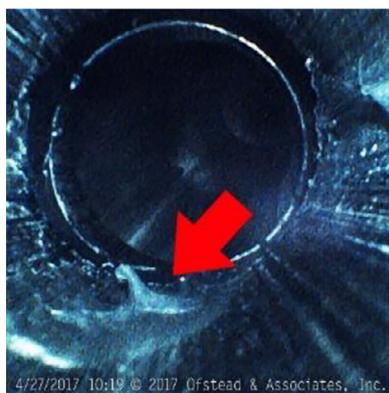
Solid mass protruding into the channel of an endoscopic ultrasound endoscope.
